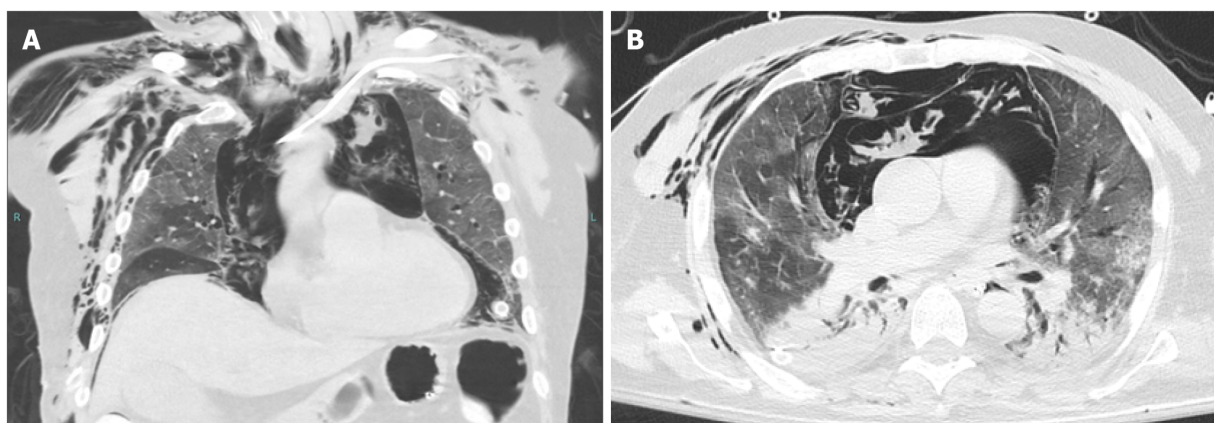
Barotrauma. A and B: Coronal (A) and axial (B) images from an unenhanced computed tomography of the chest of a 75-yr-old male with no significant past medical history, who was intubated for acute hypoxic respiratory failure secondary to coronavirus disease 2019 pneumonia. There are ground glass opacities anteriorly, as well as consolidations with air bronchograms posteriorly, a pattern typical for acute respiratory distress syndrome. There is a massive amount of air within the mediastinum resulting from alveolar rupture (Macklin effect). The arrow on image (A) points to interstitial emphysema, surrounding a pulmonary vein. The arrow on image (B) points to nonanatomic air within a pulmonary lobule, which may represent the initial barotrauma event. There is extensive soft tissue emphysema in the lower neck and lateral chest wall, as well as in the extraperitoneal space of the abdominal cavity. Bilateral thoracostomy tubes and a peripherally-inserted central catheter are in place. The patient could not be weaned from ventilation and subsequently expired.
